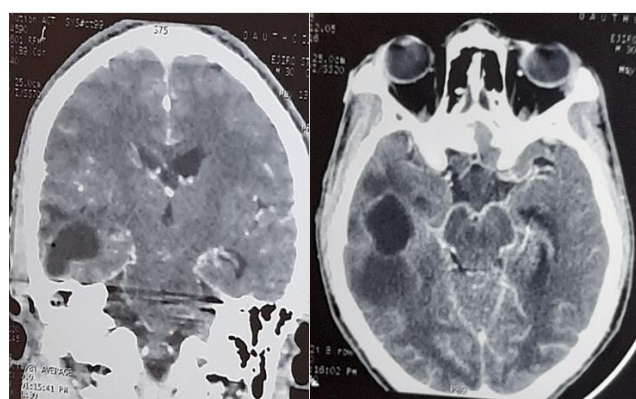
Contrast enhanced coronal and axial CT scan images of a patient with right temporal lobe amebic brain abscess showing an irregular shaped hypointense lesion with mild perilesional edema and encephalomalacia of surrounding brain tissue.
